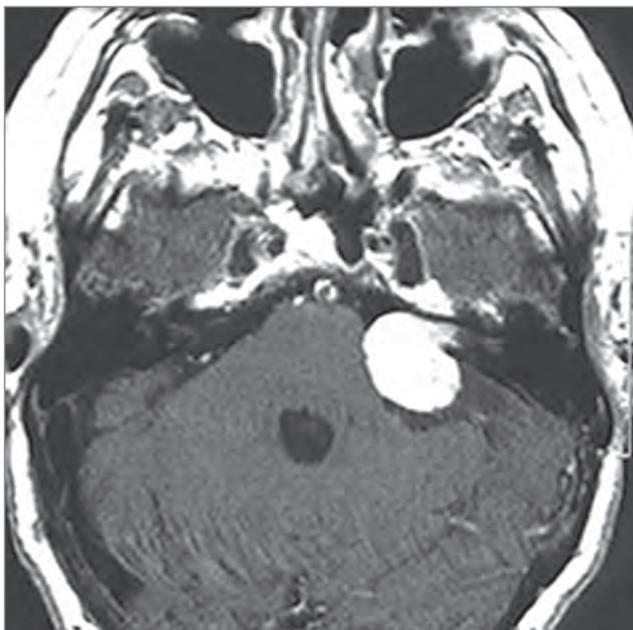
Post contrast T1-weighted axial image demonstrating an intense contrast enhancing extraaxial mass at the left cerebellopontine angle close to the left internal auditory canal (IAC) consistent with an acoustic neuroma.
